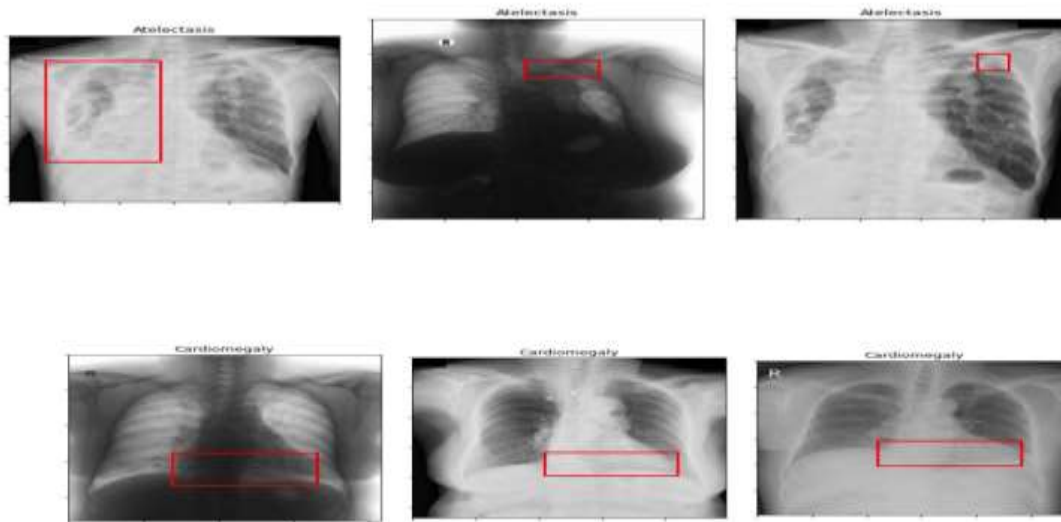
Major Abnormalities find Through X-ray System
